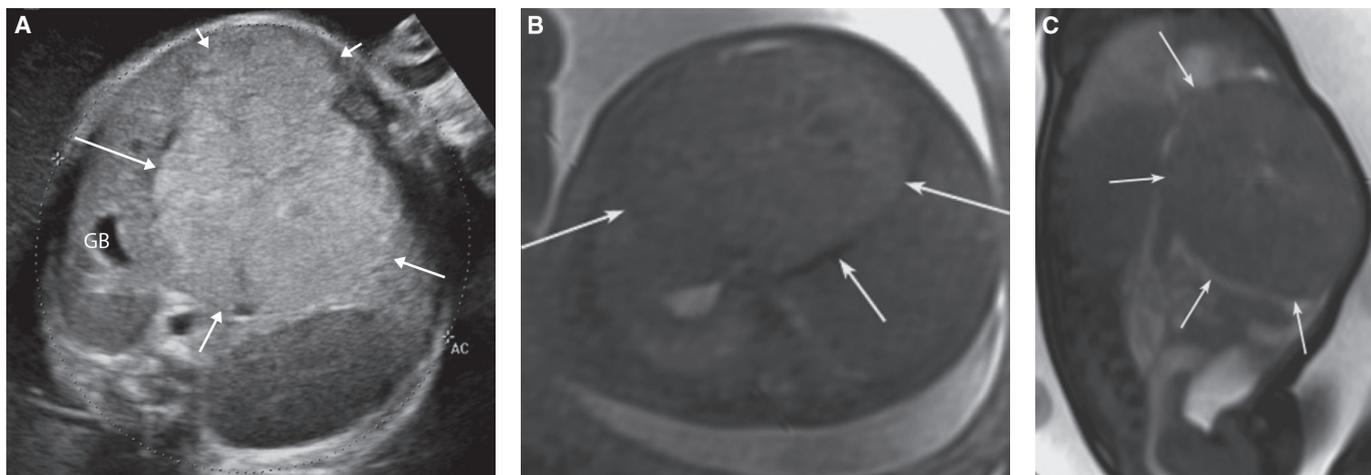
Hepatoblastoma. A: Transverse US demonstrates a large echogenic liver mass (arrows) displacing the gallbladder (GB). There are subtle linear hypoechoic structures in a spoke-wheel orientation. B: Axial T2-weighted prenatal MR image demonstrates a large liver mass (arrows) with mild hyperintense T2-weighted signal relative to liver. C: Sagittal SSFP image demonstrates mild heterogeneous signal centrally within the mass (arrows). (Reprinted from Al-Hussein H, Graham E, Tekes A, et al. Pre- and postnatal imaging of a congenital hepatoblastoma. *Fetal Diagn Ther.* 2011;30(2):157–159. Copyright © 2011, with permission from S. Karger AG, Basel, Switzerland.)⁸⁸
